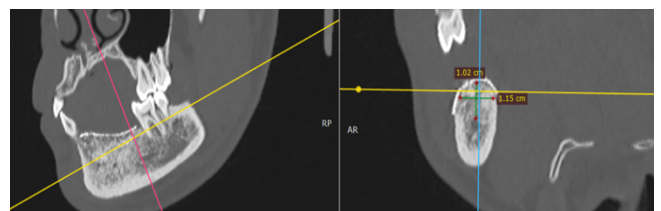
CBCT after GBR 6 months follow up.
